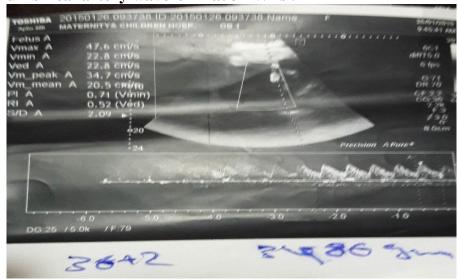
shows normalColor Doppler of the umbilical artery waveform at $36~\mathrm{Wks}$.
